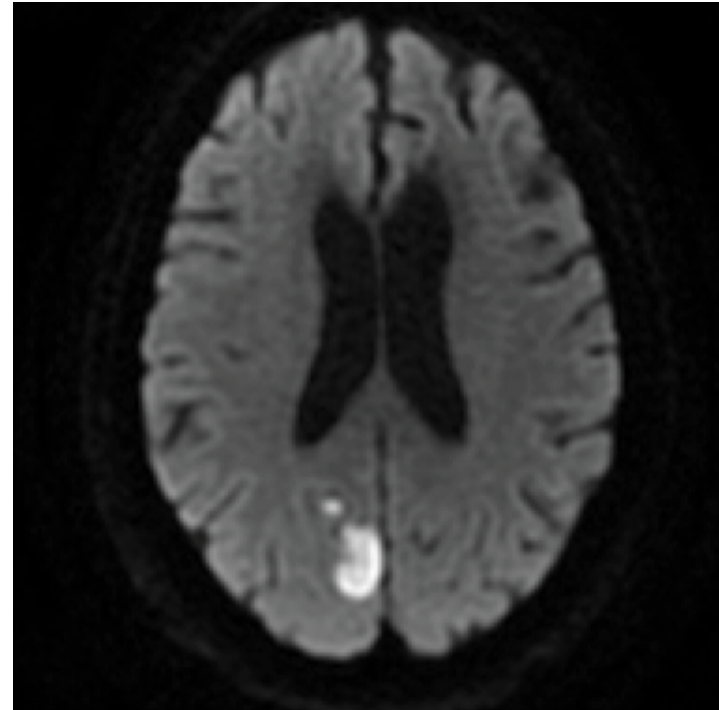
MRI of the brain w/o contrast: Acute ischemic infarct in the right occipital region (DWI).
